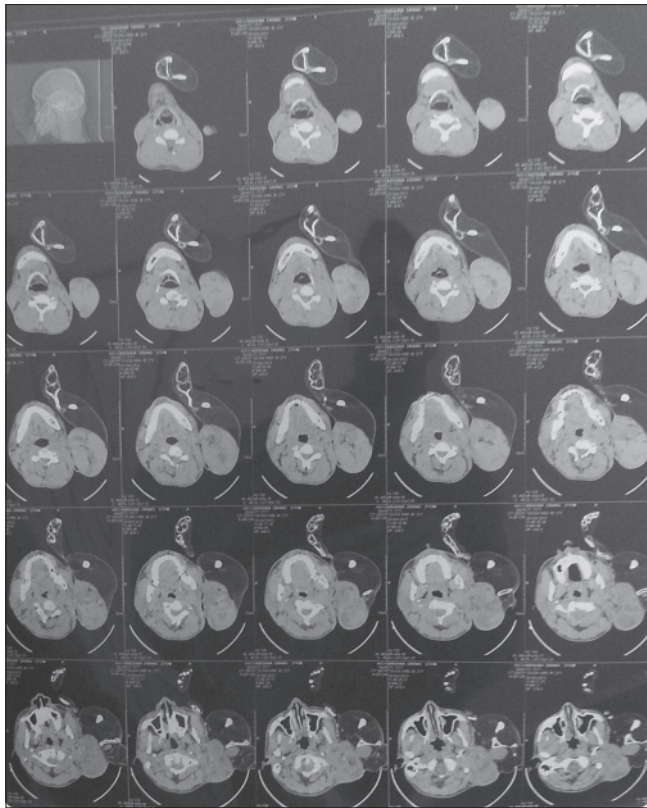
Computed tomography scan showing coronal sections at various levels
